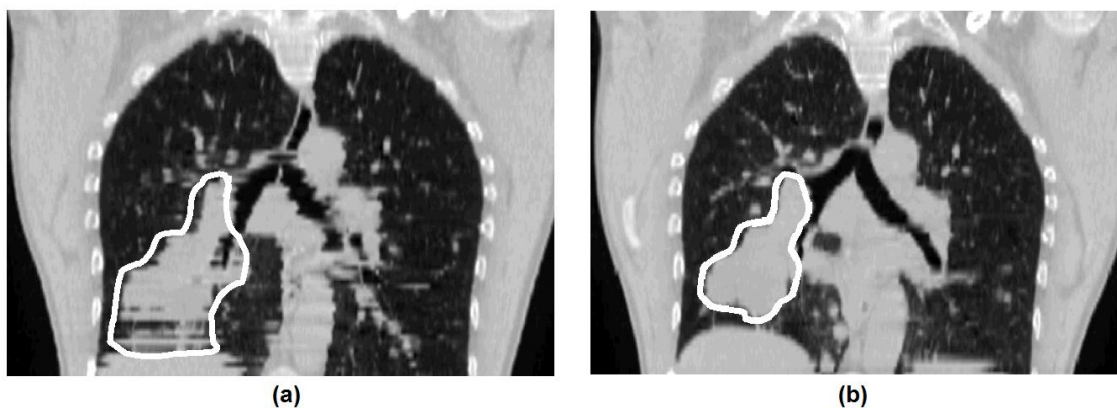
Coronal views of a CT volume of the same patient taken during free-breathing (Panel a) and with respiratory-gated scanning at end-exhalation (Panel b). The contoured tumour volume is outlined in each image [Keall 2002].
